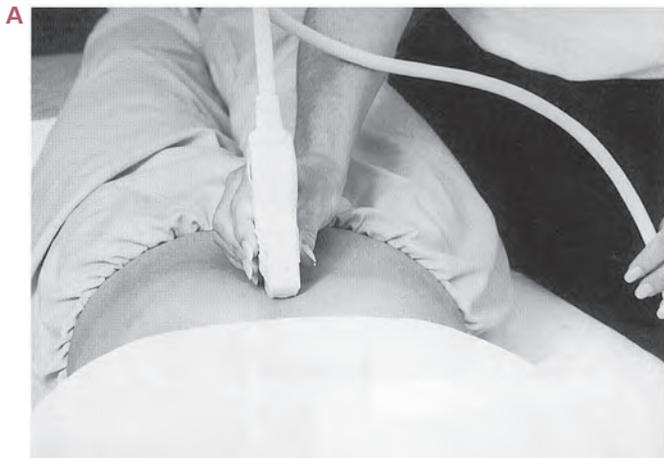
A, B Sliding the transducer from midline to the middle of the right costal. Reprinted with permission from Gill KA: Abdominal Ultrasound: A Practitioner's Guide. Philadelphia, Saunders, 2001.
